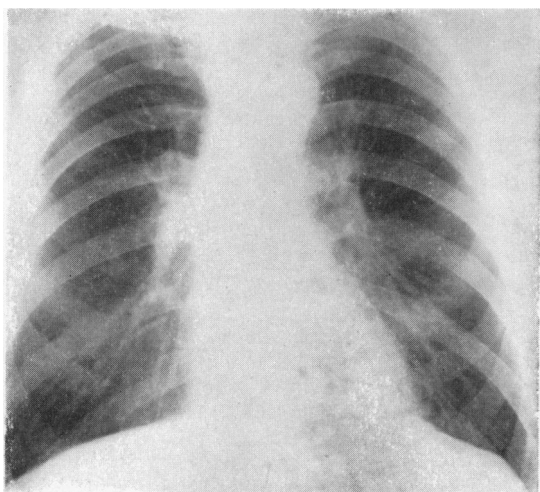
Complete regression of hilar mass during treatment with testosterone. Radiograph seven months after beginning this hormone: small lesions in left upper zone show no change.
